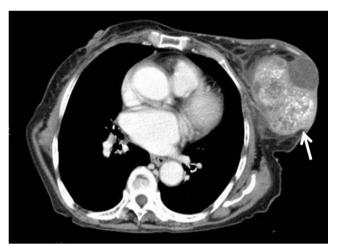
Axial enhanced chest CT image reveals a solid and cystic mass with calcification (arrow) and ill defined border
